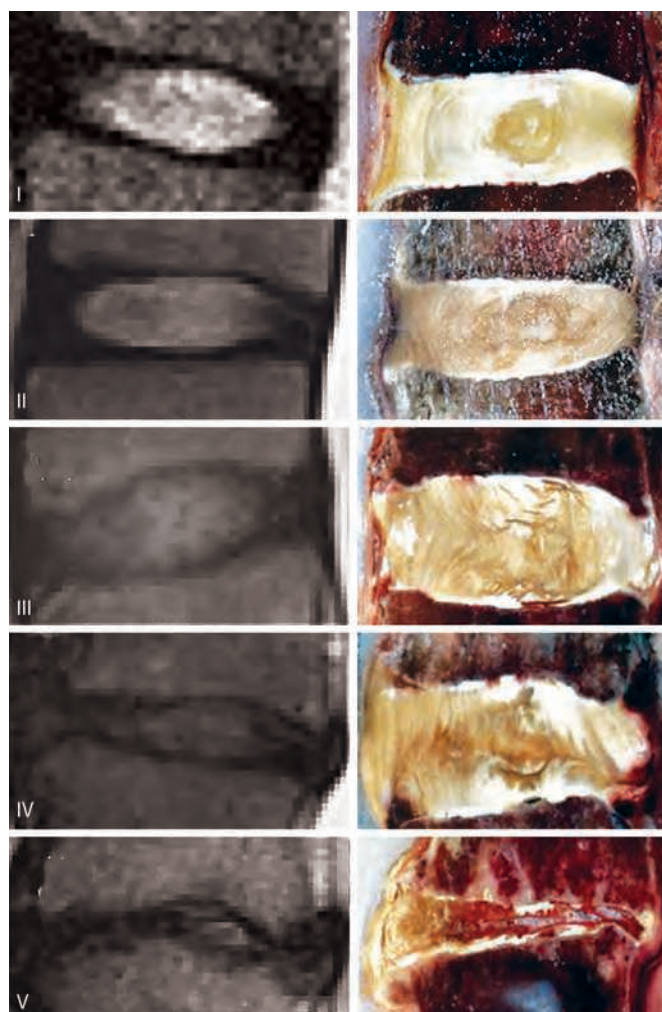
Grading disc degeneration: T2-weighted magnetic resonance images (left panel) and gross pathology mid-sagittal sections (right panel) of intervertebral discs demonstrating progression of degenerative changes from Pfirrmann/Thompson Grade I, with no degeneration to Pfirrmann/Thompson Grade V, with severe degeneration and disc space collapse.
